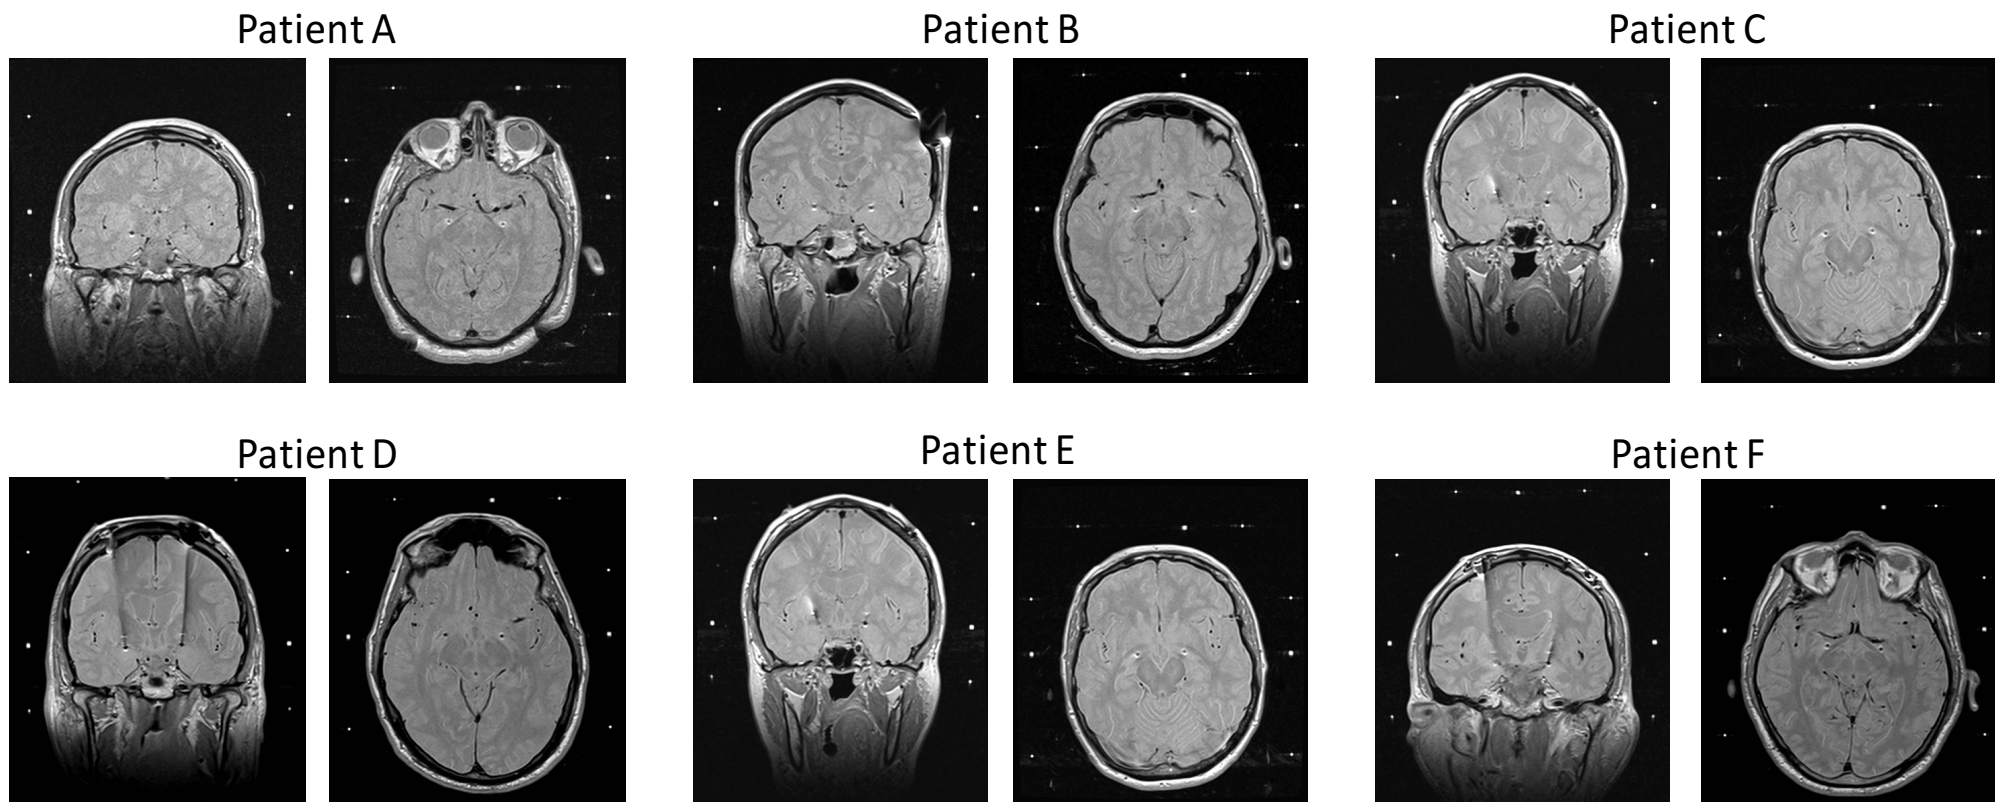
Location of active DBS contacts for each patient on their individual MRI images (Patients A through F). The locations of the most ventral active contacts (in NBM) are shown on representative coronal and axial post-operative MRI images for each patient, and correspond to those shown in Figure 14a above.
